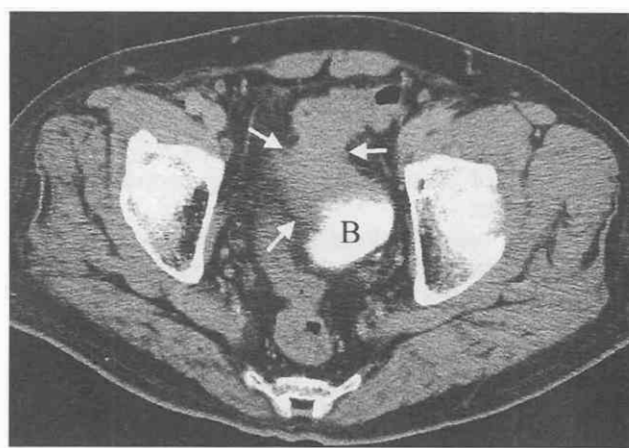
Sigmoid colon cancer with bladder invasion. CT scan shows irregular bowel wall thickening of the sigmoid colon (arrows). The superior part of the bladder (B) is irregular because of direct tumor invasion.
